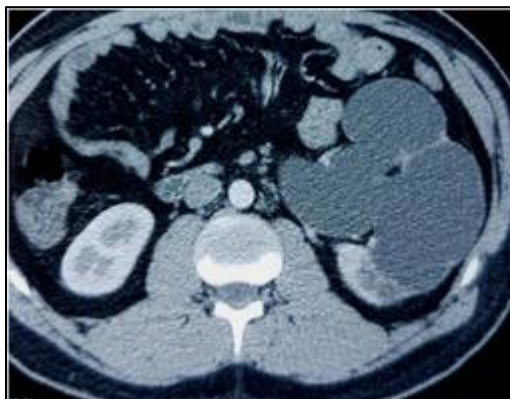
CT scan of the patient revealed left side important hydronephrosis
